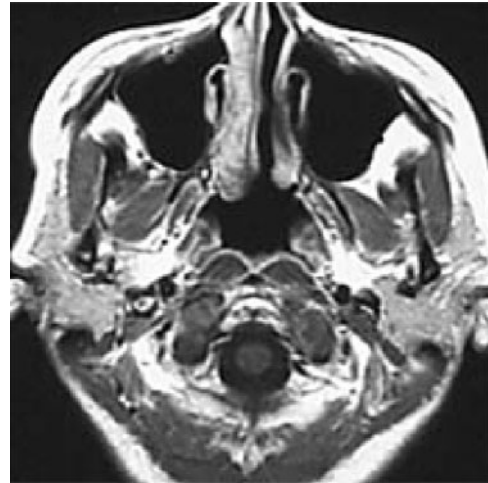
A 31-year-old woman presenting with Type 1 (superficial type) spread. Axial T_1 weighted MR image, Gd-DTPA enhanced, shows no abnormal findings in the nasopharyngeal mucosal space.
